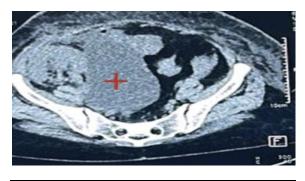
CT KUBU-ONE MONTH POST TRANSPLANT
